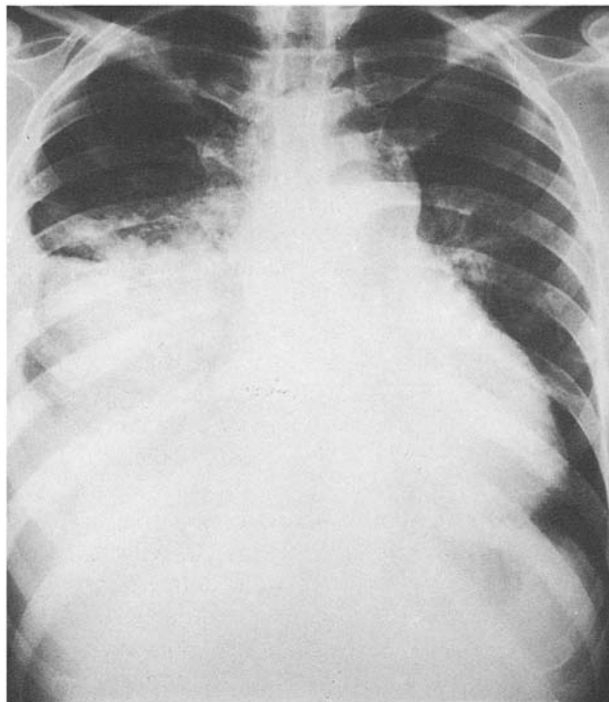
Chest X-ray of case no. 14 at start of chemotherapy. Pleural effusion contained plasma cells
